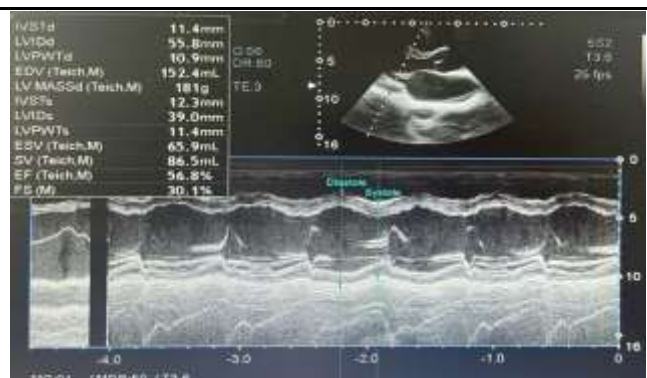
Initial Doppler echocardiography: Mild aortic valve regurgitation, moderate 2/4 mitral valve regurgitation, 2/4 tricuspid valve regurgitation, and 2/4 pulmonary valve regurgitation, less pericardial fluid. Mild increase in pulmonary artery pressure (35 mmHg), dilated cardiac chambers, no cardiac movement disorders, preserved left ventricular systolic function (EF 62.6%).
